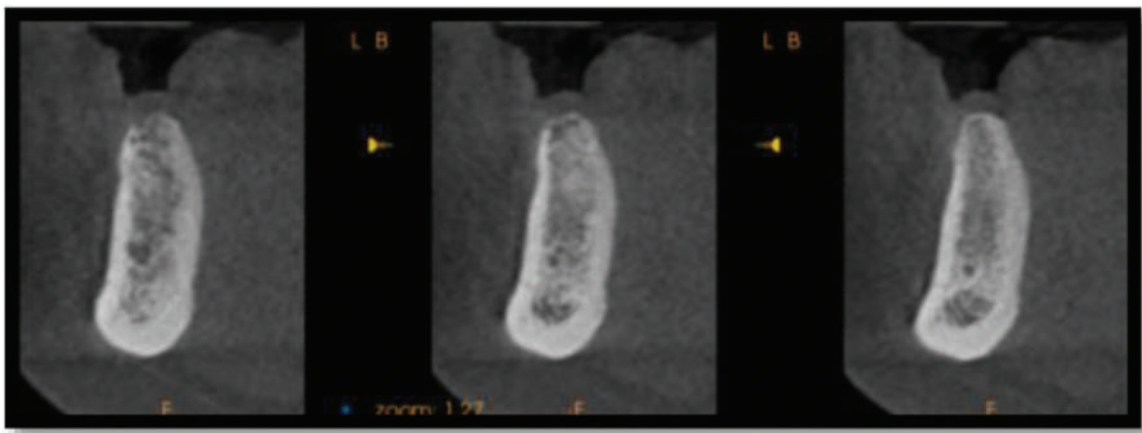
CBCT images with anterior loop length in cross-sectional slice view. CBCT, cone-beam computed tomography
